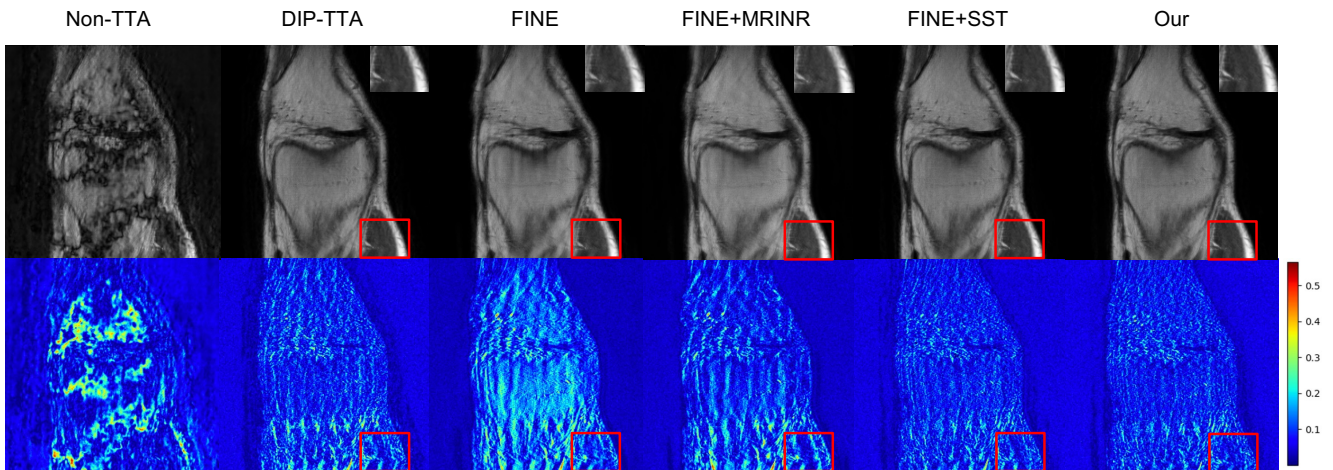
Comparison of different frameworks in VarNet under dataset shift (Stanford to fastMRI) using the FINE method. The first row shows reconstructed MRI images, while the second row presents residual maps between reconstructions and full-sampled MRI. The proposed method (far right) achieves the lowest residuals, indicating improved reconstruction accuracy
